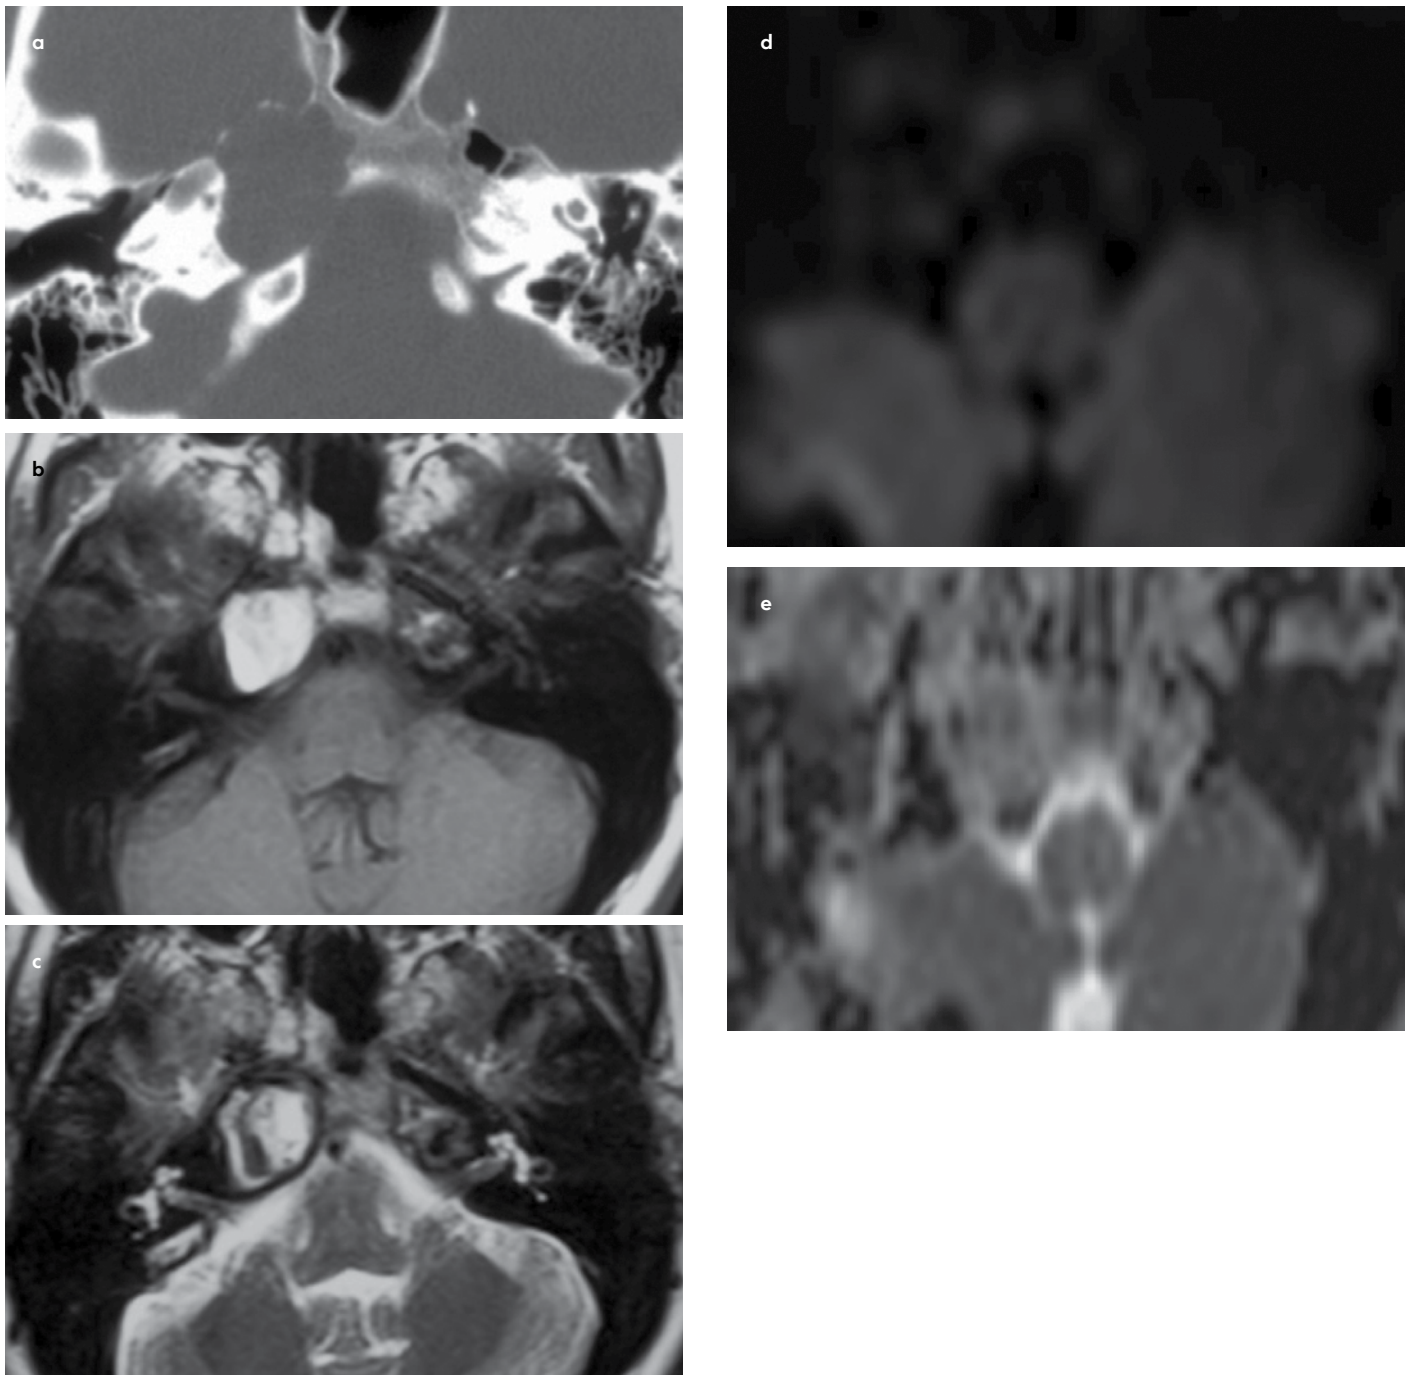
a-e. Cholesterol granuloma. An axial CT scan (a), T1- (b), and T2-weighted axial MR images (c) demonstrate expanded right petrous apex. The lesion shows high T1 and high T2 signal intensity consistent with cholesterol granuloma. The b1000 DW image (d) and corresponding ADC map (e) show no restriction in diffusion. The dark peripheral rim is due to hemosiderin.
